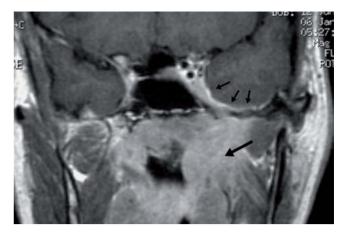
MRI and CT scans are complementary and help distinguish between tumour, retained secretions and dural infiltration. This patient had an extensive tumour that had spread into the cavernous sinus, infiltrated the dura of the temporal lobe (small arrows) and the infratemporal fossa (large arrow). The MRI, shown here, shows the true extent of the disease. The spread was not apparent on the CT scan, which had shown a relatively small tumour affecting the sphenoid.
